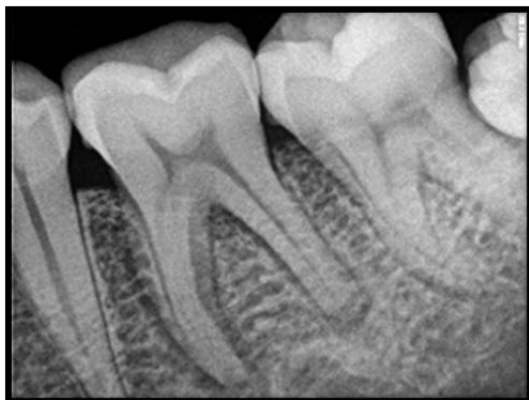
Pre-op radiograph
